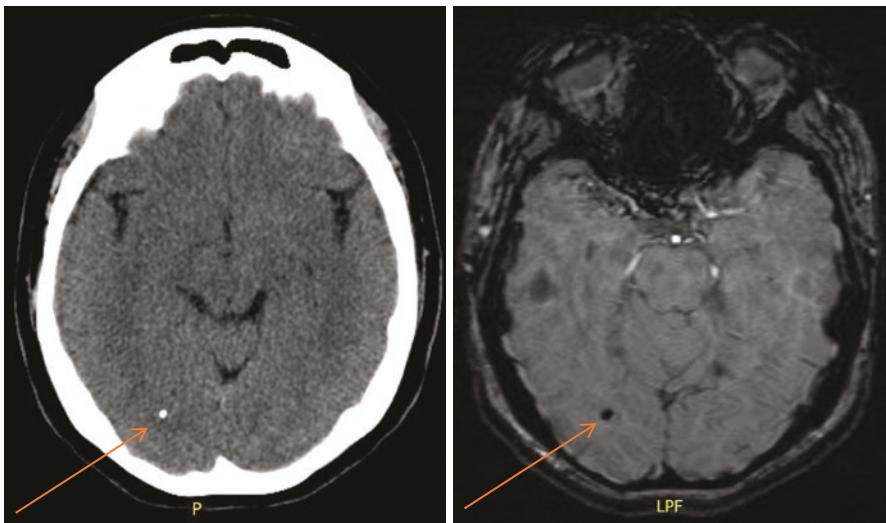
CT head (left) and axial SWI MRI (right) images in a 36-year-old Hispanic woman showing a small calcification in the right occipital lobe likely representing sequela of remote neurocysticercosis
